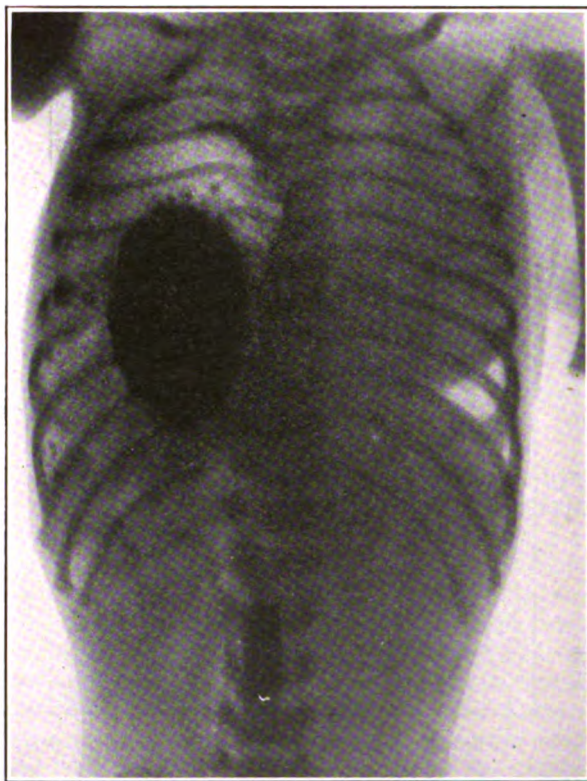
Incomplete diaphragmatic hernia (case of Dr. Irving Stein). Roentgenogram taken three and six hours after ingestion of bismuth. Stomach and bowel in chest.
